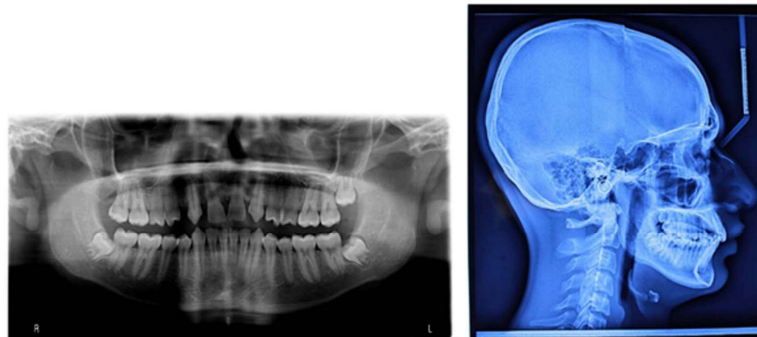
Radiographs before treatment
